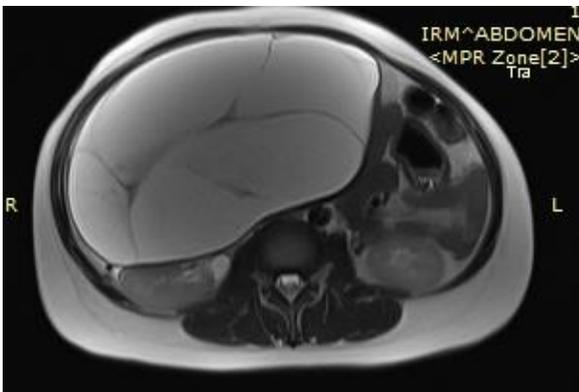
Magnetic resonance Imaging of abdomen revealed a
